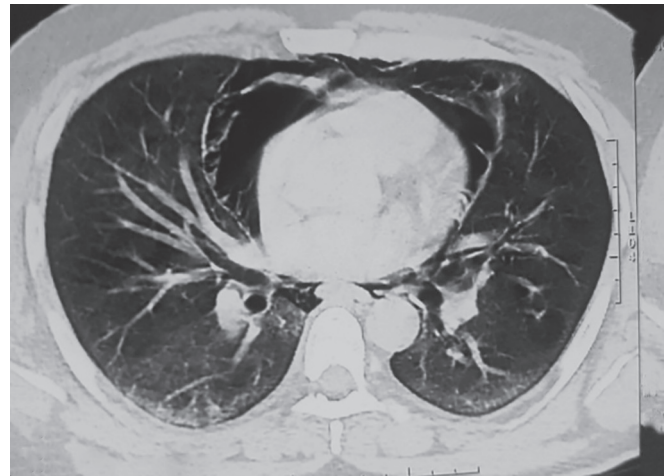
Axial section HRCT chest, revealing mild inter- and intra-lobular septal thickening with fine reticular pattern, ground glass attenuation and pneumomediastinum
